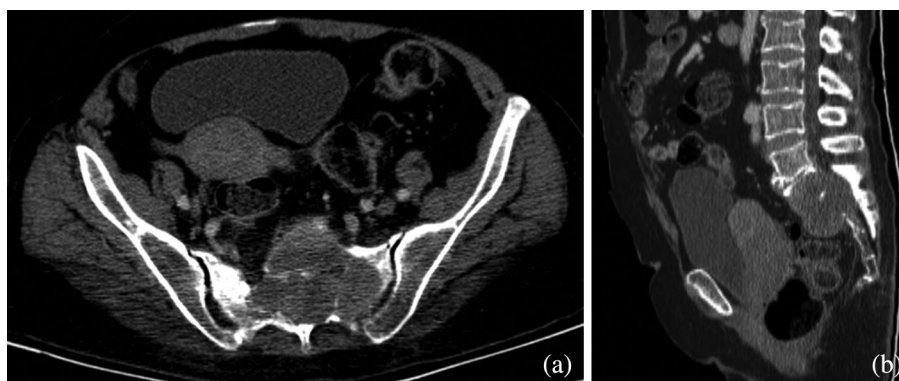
(a) CT demonstrating the osteolytic lesion of the sacrum invading the surrounding tissue in all aspects along with the spinal canal. (b) Sagittal reconstructed view of the CT showing the anterior and posterior invasion of the mass encompassing the S1 and S2 vertebral body
